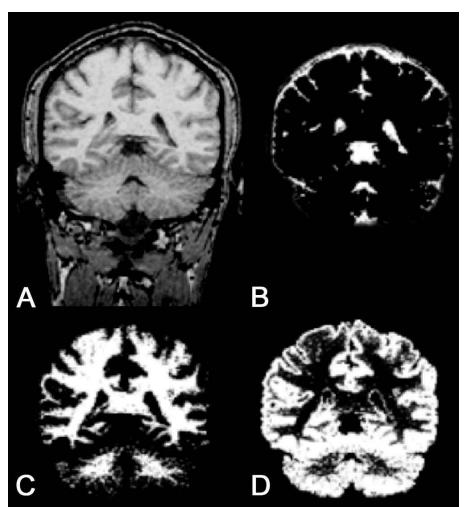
Representative tomographic MRI slice showing segmentation into grey and white matter obtained using Statistical parametrical mapping (SPM99) at the Buffalo Neuroimaging Analysis Center. Shown are (a) the source image (high-resolution T1-weighted gradient echo), (b) after masking and segmentation into brain parenchyma (black) and CSF (white), (c) segmentation into white matter (white areas), and (d) segmentation into grey matter (white areas).
